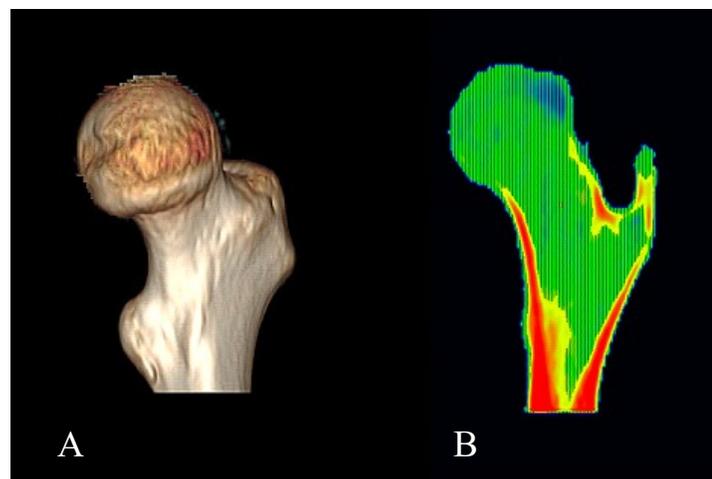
(A) Cut 3D femur, (B) 2D CT image showing (bright grey) cortical and (dark grey) trabecular bone delineation.
